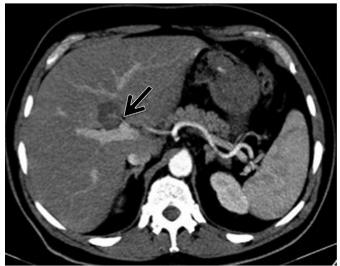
Images in a 39-year-old woman with focal steatosis in segment 4. (a) In- and (b) opposed-phase GRE T1-weighted MR images (236/2.2 and 4.4; flip angle, 80°; section thickness, 4 mm) show drop of signal intensity in the posterior part of the segment 4 on opposed-phase image related to focal steatosis. (c) On axial contrast-enhanced MIP CT image obtained at the portal phase, a duodenopancreatic vein (arrow) enters directly in segment 4.
